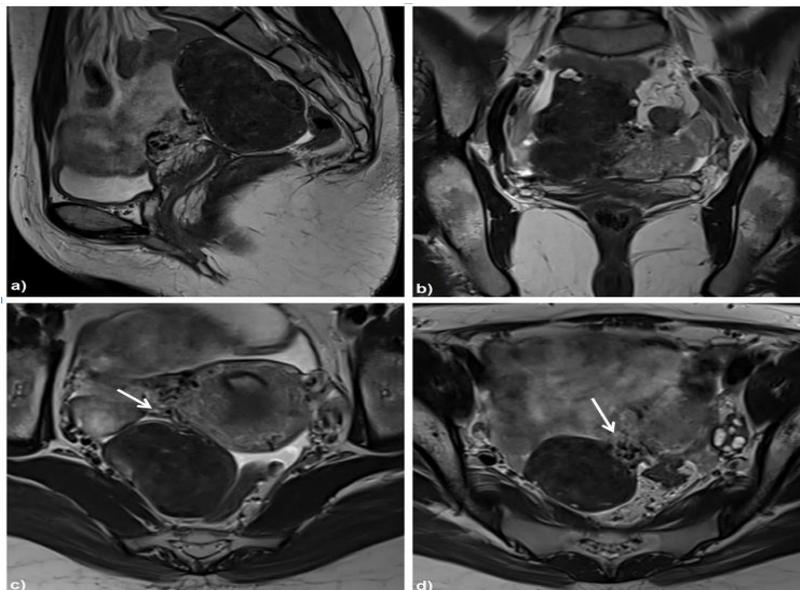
MRI pelvis showing a large uterine subserosal fibroid; a) & b) Sagittal & coronal T2W images showing a large hypointense lesion in the right adnexa. Right ovary is seen separately from this lesion. c) & d) are axial T2W images showing bridging vessels (arrow) between the lesion and right postero-lateral wall of uterus confirming sub serous fibroid.
